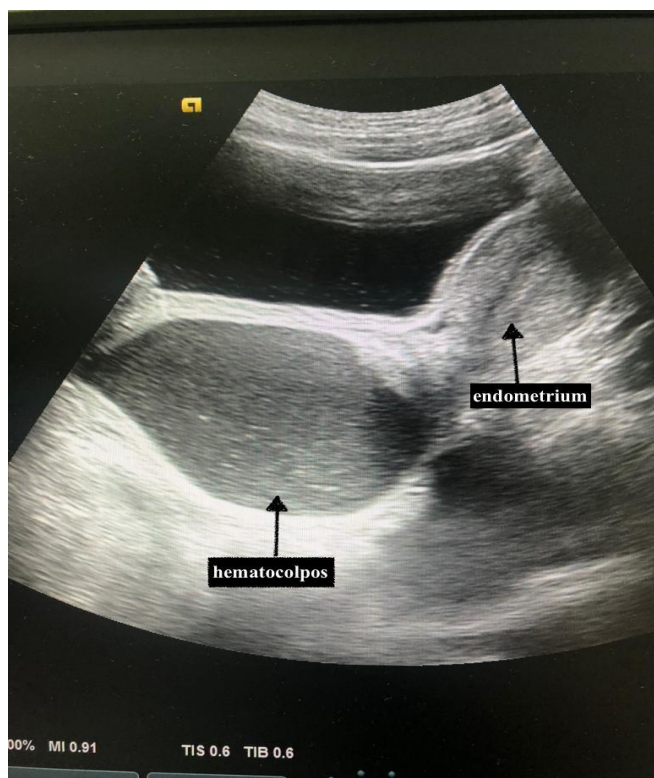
Ultrasonographic view of the hematocolpos and normal uterus in sagittal plane.
